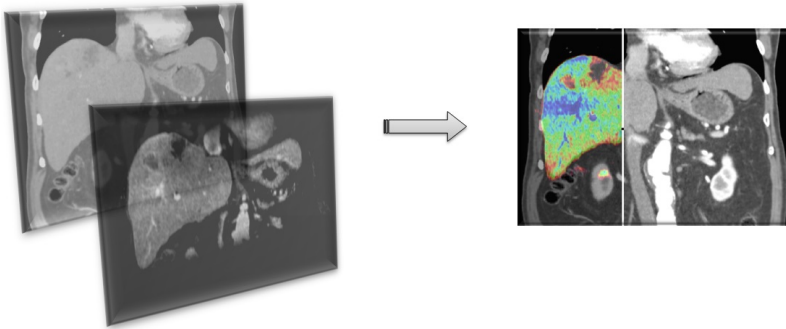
Multi-modality image registration (CT and MR images)
